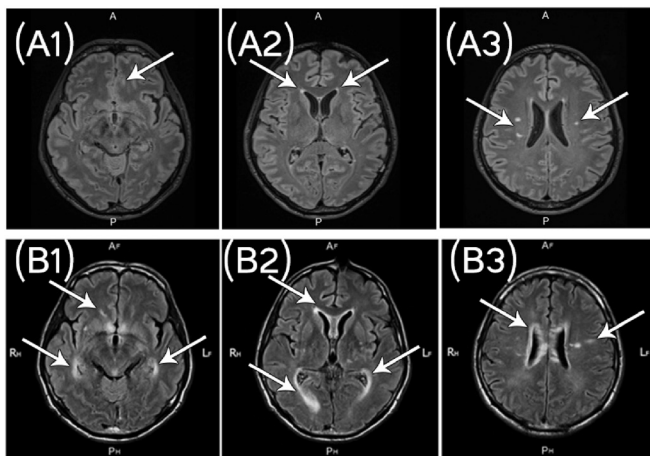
MRI brain horizontal T2-weighted images. Imaging made at the first presentation (A series images) and ninety-five days after (B series images). On series A hyperintense lesions are depicted in frontal lobes (A1) and paraventricular regions (A2, A3). On series B the lesions' expanding is demonstrated in frontobasal lobes (B1), paraventricular and periventricular regions (B3), occipital lobes (B2) and temporal lobes (B1).
